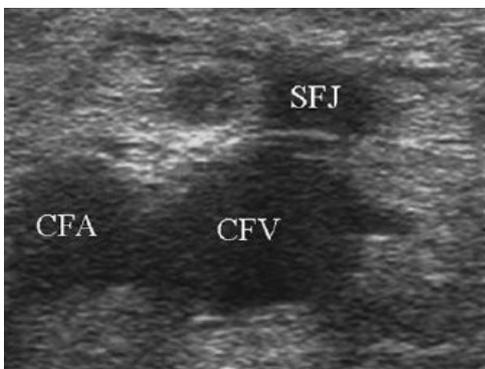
Ultrasound of common femoral artery(CFA) and common femoral vein(CFV) [25]
